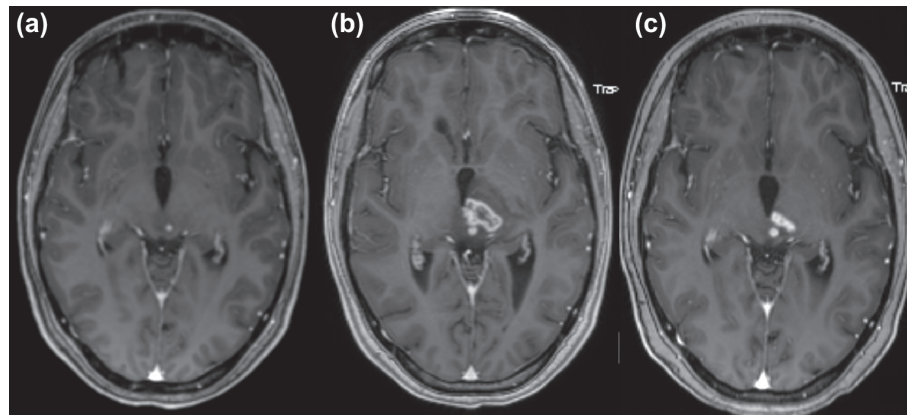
MRI T1-weighted image with contrast before and after proton radiotherapy. (a) MRI before proton radiotherapy showing a small area of contrast enhancement in the left superior colliculus. (b) MRI four months after completion of proton therapy showing progression of contrast enhancement. (c) MRI 10 months after completion of proton therapy showing decrease in contrast enhancement.
